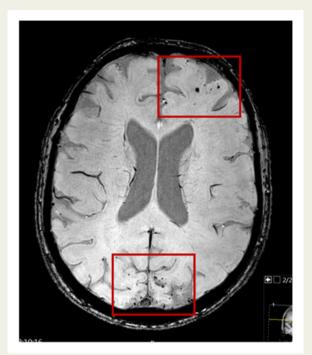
Magnetic resonance imaging with lobar microbleeds— 3T magnetic resonance imaging, susceptibility weighted imaging.
